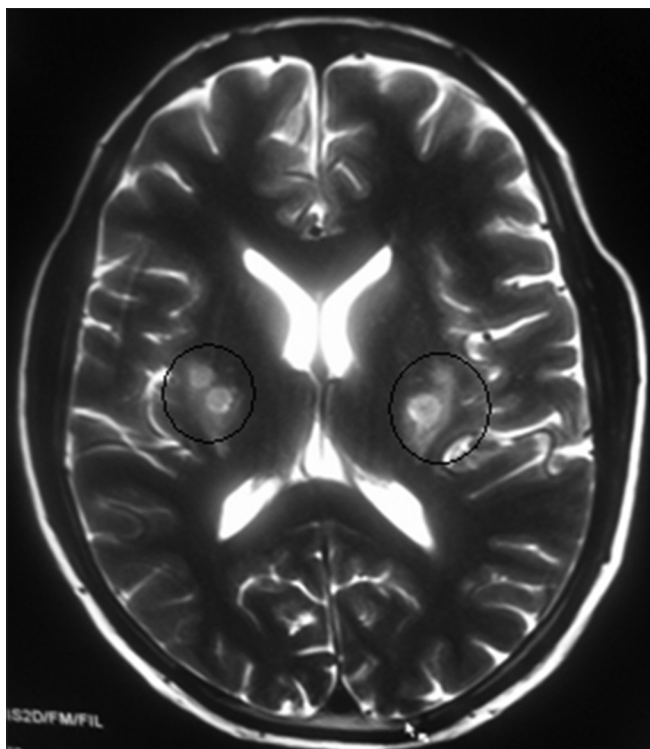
MRI brain axial section showing putamen necrosis
